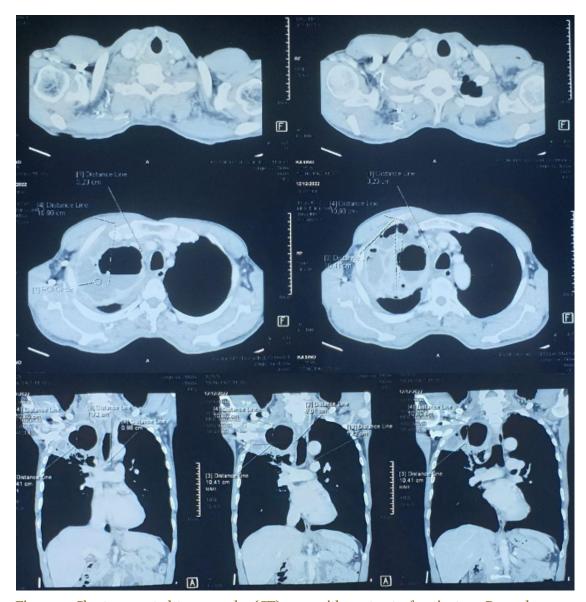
Chest computed tomography (CT) scan with contrast of patient on December 2022 indicating a massive abscess with a size 10.9 x 10.41 x 8 cm on the right lung segment.
